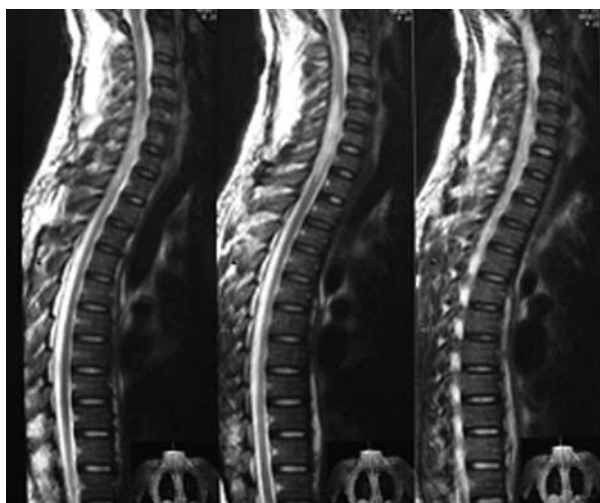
T2 MRI Image shows hyper-signal cord expansion in C5-T2 segment of spinal cord.
